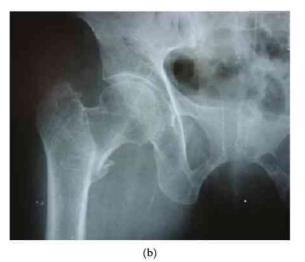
(a) X-ray of femur showing pathological fracture due to osteoporosis. (b) X-ray of right hip anteroposterior view showing fracture neck of femur.
